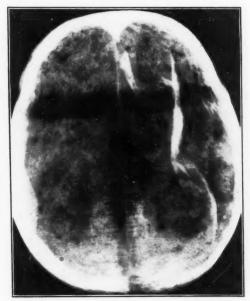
X-ray of vault of skull (Postmortem) showing marked separation of suture lines by extensive tumour processes.
